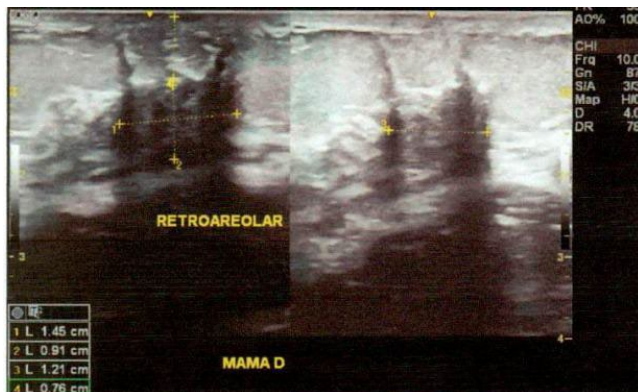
Retroareolar ultrasound of the right breast. Solid, oval, slightly heterogeneous nodule, circumscribed margins, horizontal orientation, no vascular flow detected, retroareolar location, 0.6 cm from the skin and measuring 0.9 x 0.8 x 0.9 cm.
